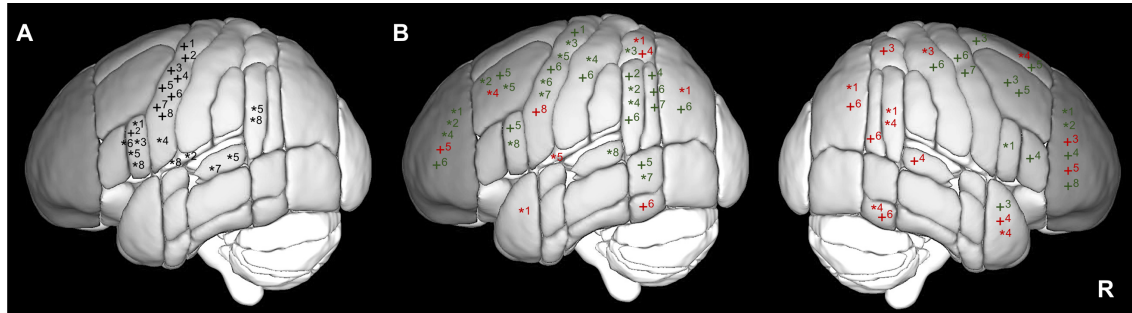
Direct cortical stimulation (DCS) sites displaced in a parcellated cortical surface by Harvard-Oxford atlas.¹⁷⁰ For predominantly evoked motor language disturbances a marker + was used, whereas a marker * was used for cognitive processing disturbances for each patient (marker plus patient number) B – Functional correlated regions with DCS sites showed in A using the same description. In addition, a green marker was used to indicate a positive correspondence with task-specific functional magnetic resonance imaging, whereas a red color indicates the absence of correspondence.
